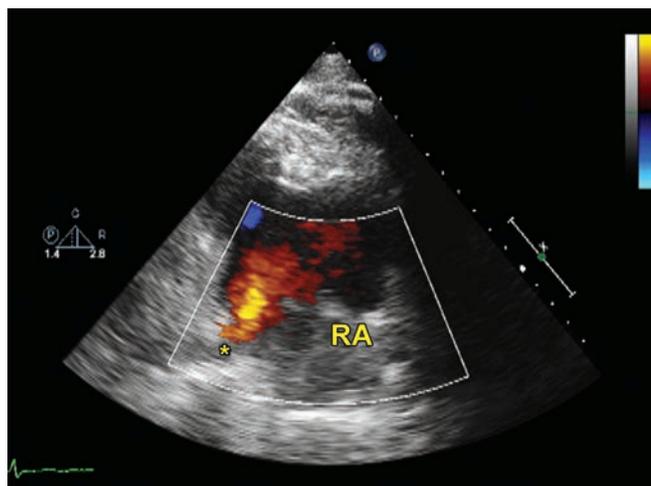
Right parasternal examination. Flow signals are visualized moving from the coronary sinus (asterisk) into the RA.
